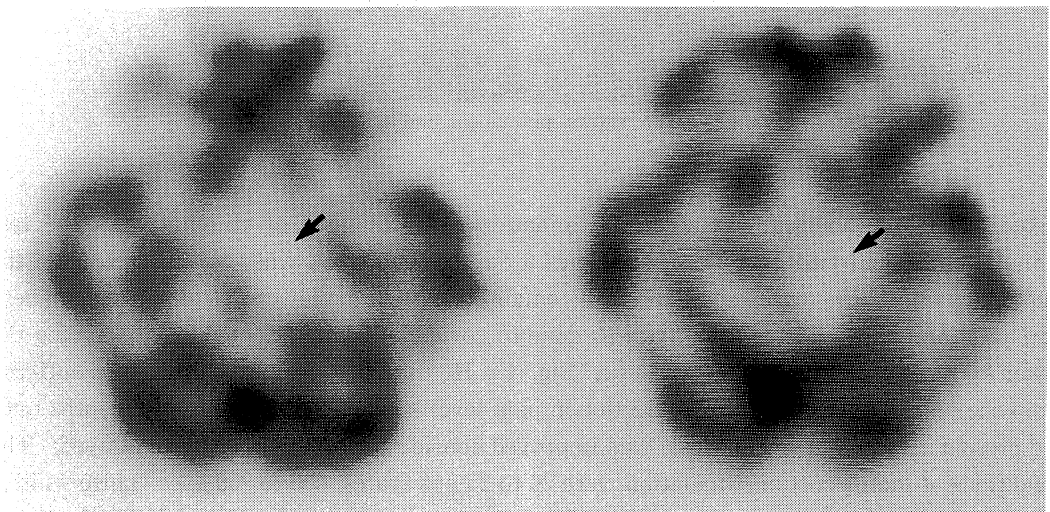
Serial single photon emission computed tomography (SPECT) demonstrates remarkable hypoperfusion area in the right basal ganglia (arrow).
